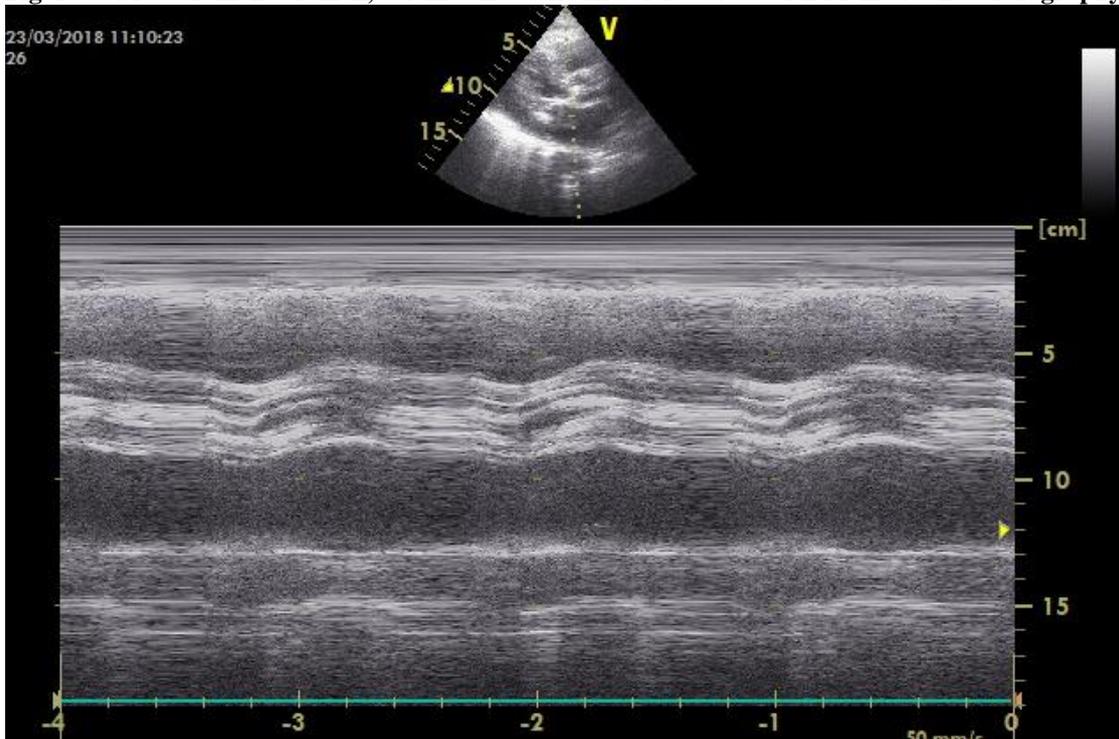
Measurement of thick, calcific and stenotik aortic valves with M-mod echocardiography.
